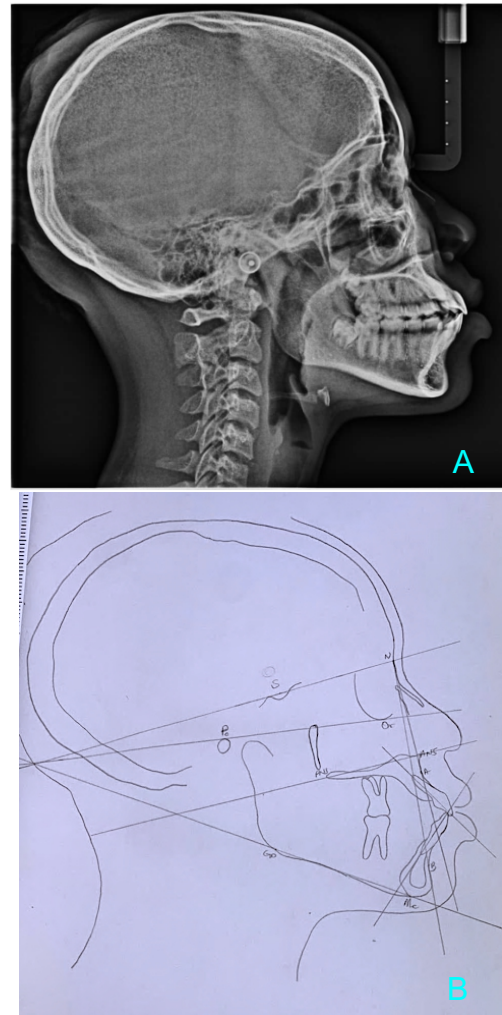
Initial lateral cephalometric radiograph and tracing
